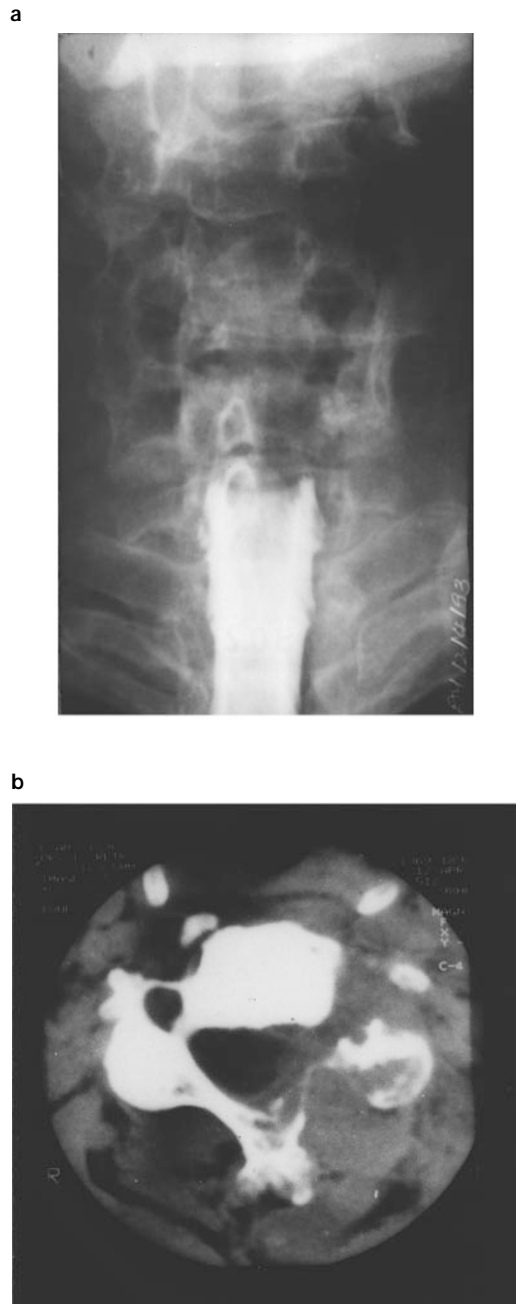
(a) Iohexol myelogram of the cervical region (AP view) demonstrating a complete block at C6–7 level. (b) Intrathecal contrast CT scan at C4 level demonstrating erosion and destruction of the lamina, pedicle and the transverse process on the left side
